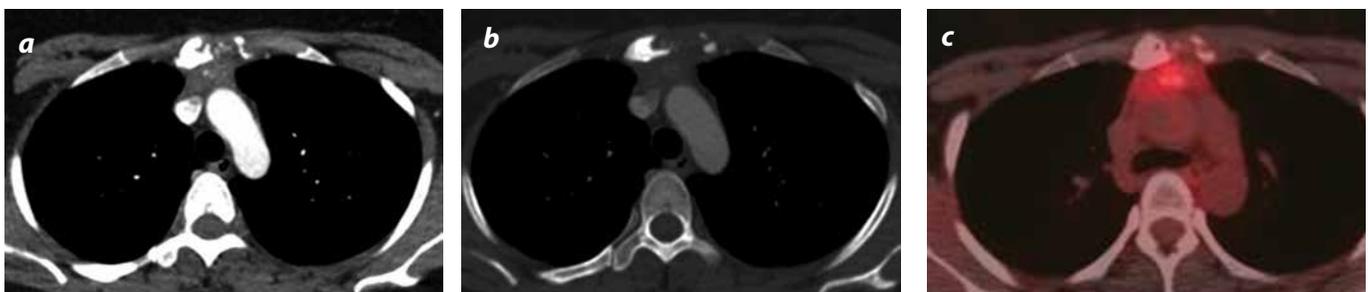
a) Contrasted CT of the thorax in soft tissue window, b) in bone window: decrease in size of the lesion compared to previous study. Invasion to the sternum and thoracic wall persists. c) PET, decrease in the acquisition of the fluorodeoxyglucose is identified.
